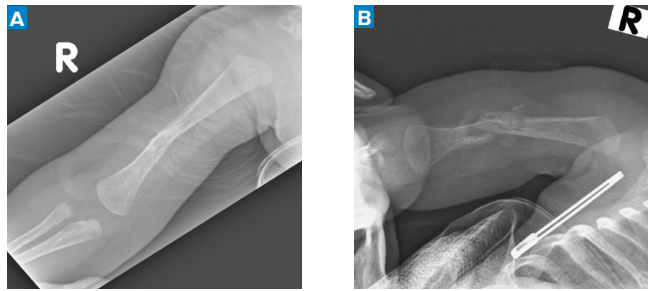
A) This X-ray of the patient at 8 weeks old shows the humerus fracture that was discovered while the patient was in the PACU. B) This X-ray was taken 2 weeks after the identification of the humerus fracture and shows callus formation and periosteal reaction.
